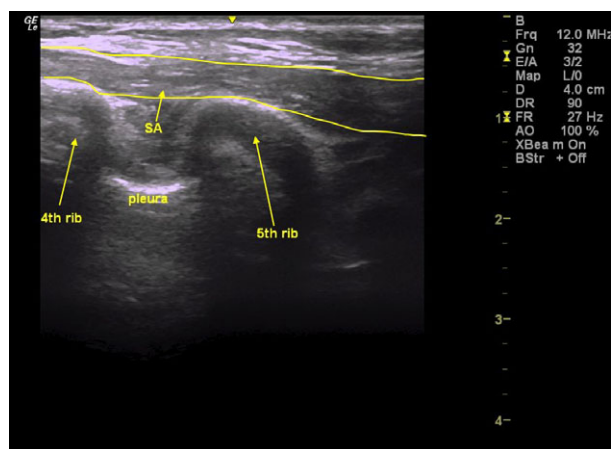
Ultrasound image of serratus anterior (SA) muscle.
